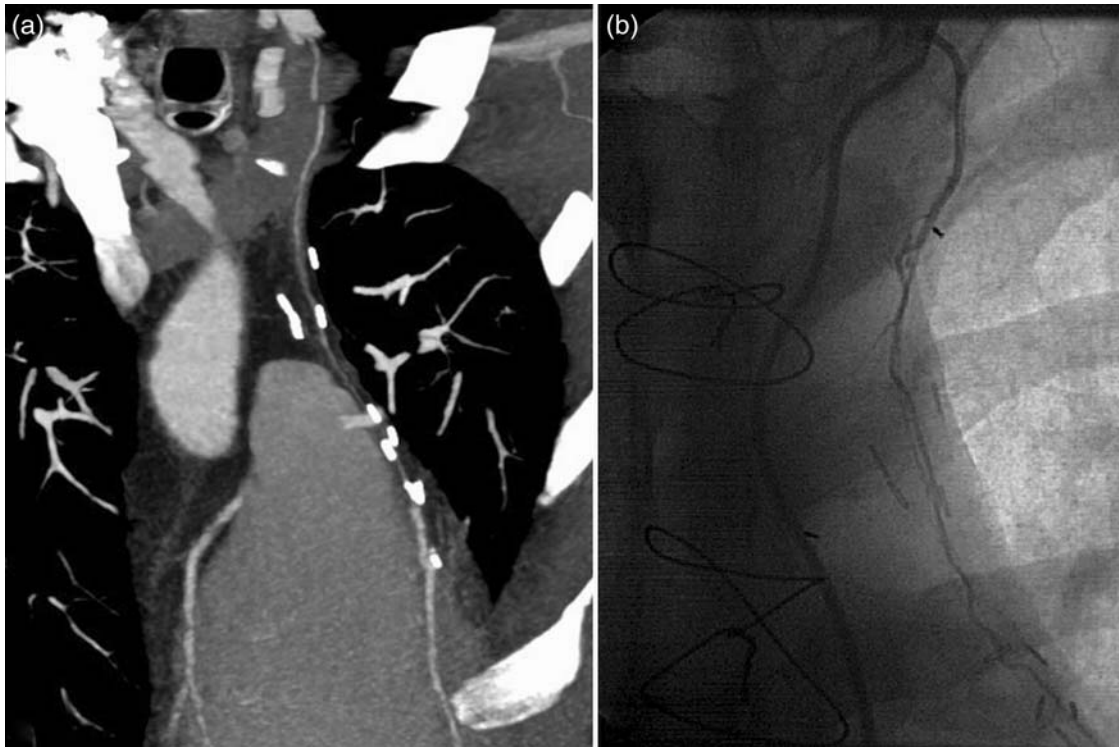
A 58-year old male patient who underwent CABG 14 months ago presented with exertional dyspnoea. 64-Slice CT coronary angiography showed patent LAD-LIMA graft with small calliper (a). Invasive coronary angiography also confirmed the diagnosis of patent LIMA graft with small calliper (b).
